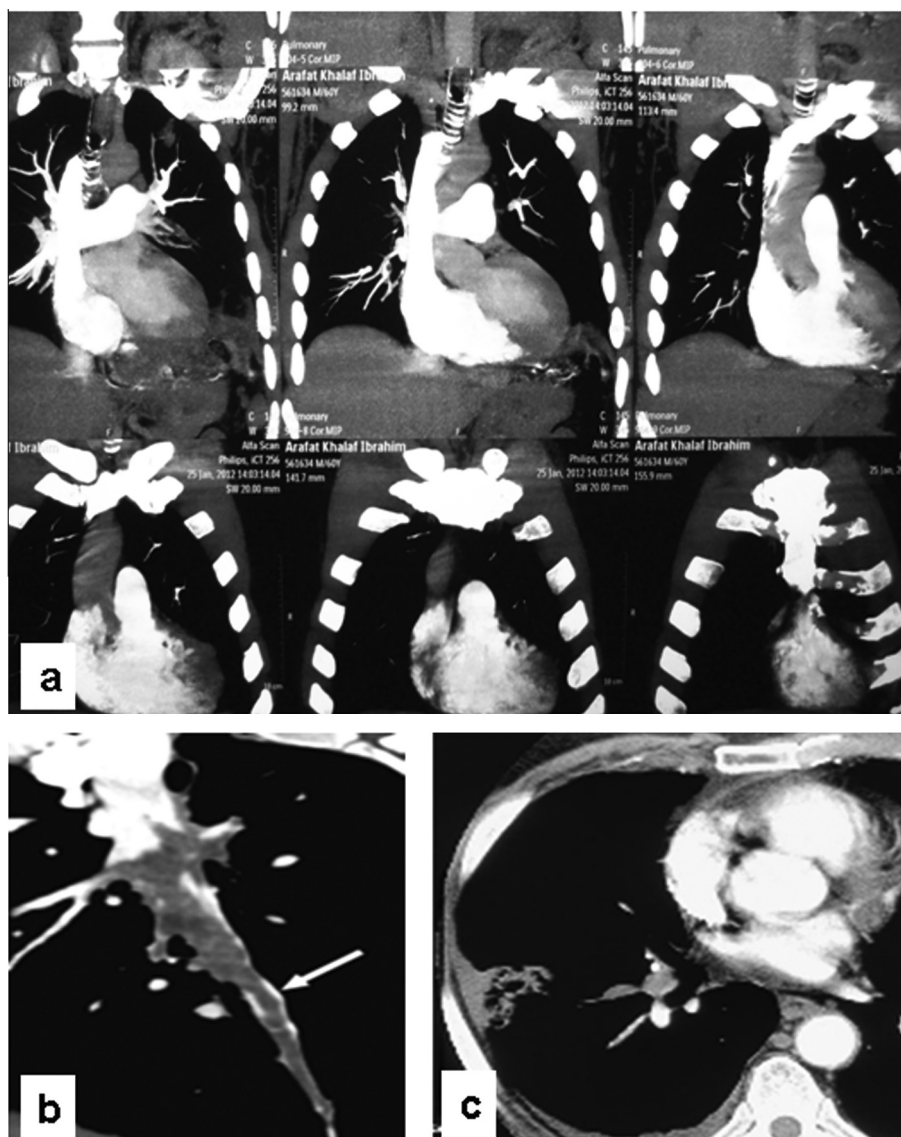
(a) showed bilateral pulmonary embolism more on left side with pulmonary infarcts. (b) reformatted image of left lower lobe branch filling defect, arrow (c) axial CT image of right lower lobe with distal lung infarction and minimal pleural effusion.
